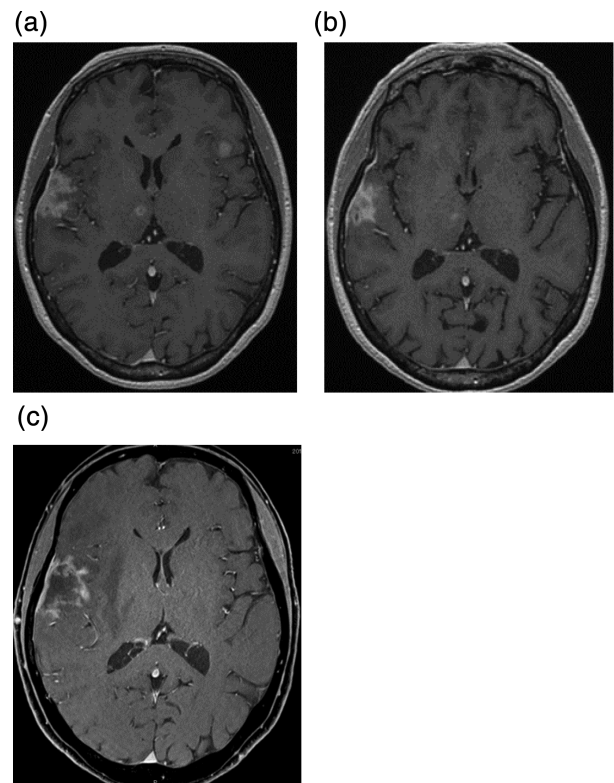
Brain magnetic resonance imaging (MRI). T1 weighted images with contrast enhancement. (a) Multiple brain metastases were found at the time after focal radiation. (b) The brain metastases lesions were controlled for four months after lorlatinib treatment. (c) The lesion in the right temporal lobe had enlarged with severe parenchymal edema six months after lorlatinib treatment
